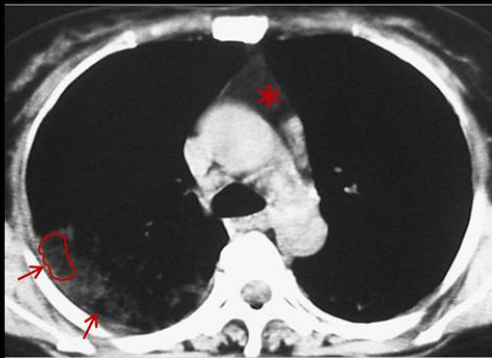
47 year-old smoker, using oily nasal drops for his chronic sinusitis, presented with subacute dyspnea and abnormal chest radiograph. Lung window CT image (a) shows ill-defined parahilar ground-glass opacity and areas of consolidation in the posterior lung. Soft-tissue window CT image at the same level (b) shows areas of low attenuation (arrows) within the consolidation. This low attenuation is similar to the mediastinal fat (*).
